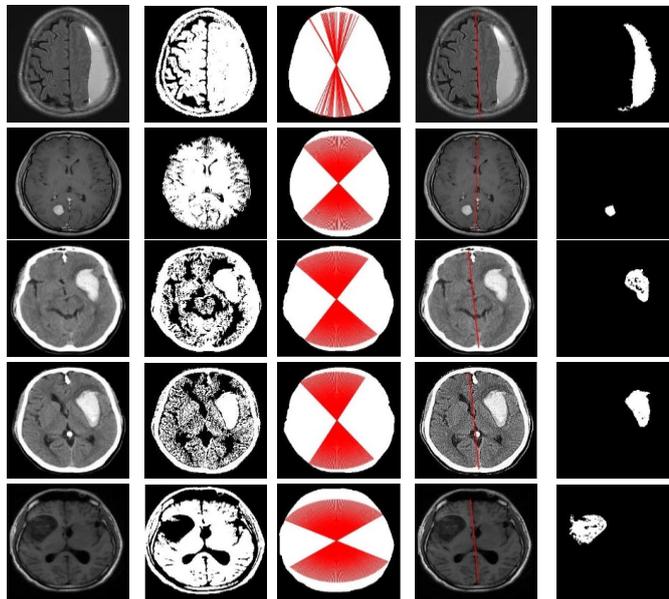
Examples of Extracted Mid-Sagittal Plane and detected tumor lesion from T1-Weighted MRI brain axial slice, (first column) Original images, (second column) Output images after thresholding, (third column) Binary images with Filling holes, with indicated the set of equal intensity longer lines by red lines, (forth column) Output images with detected MSP, (fifth column) Labelling of the detected tumour.
